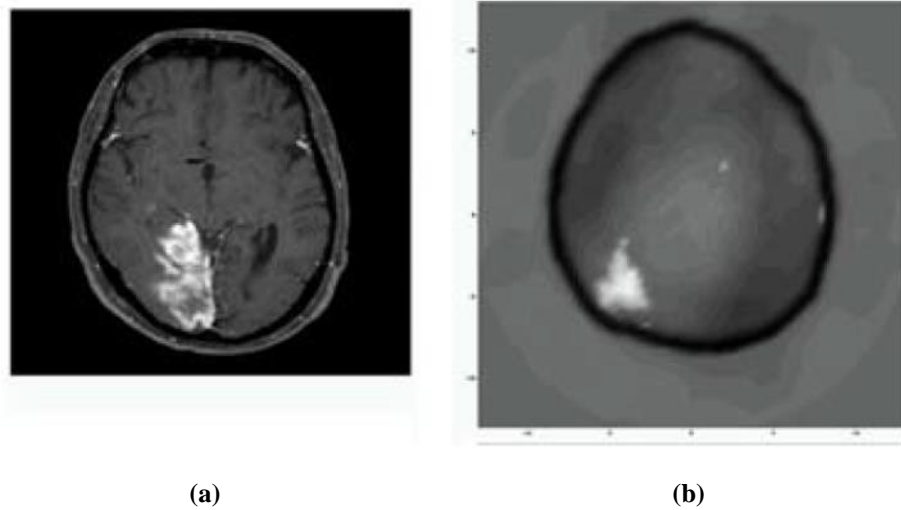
Images of a patient's head with stroke probe at 0.95GHz. (a) MRI image and (b) EMT image [8]
